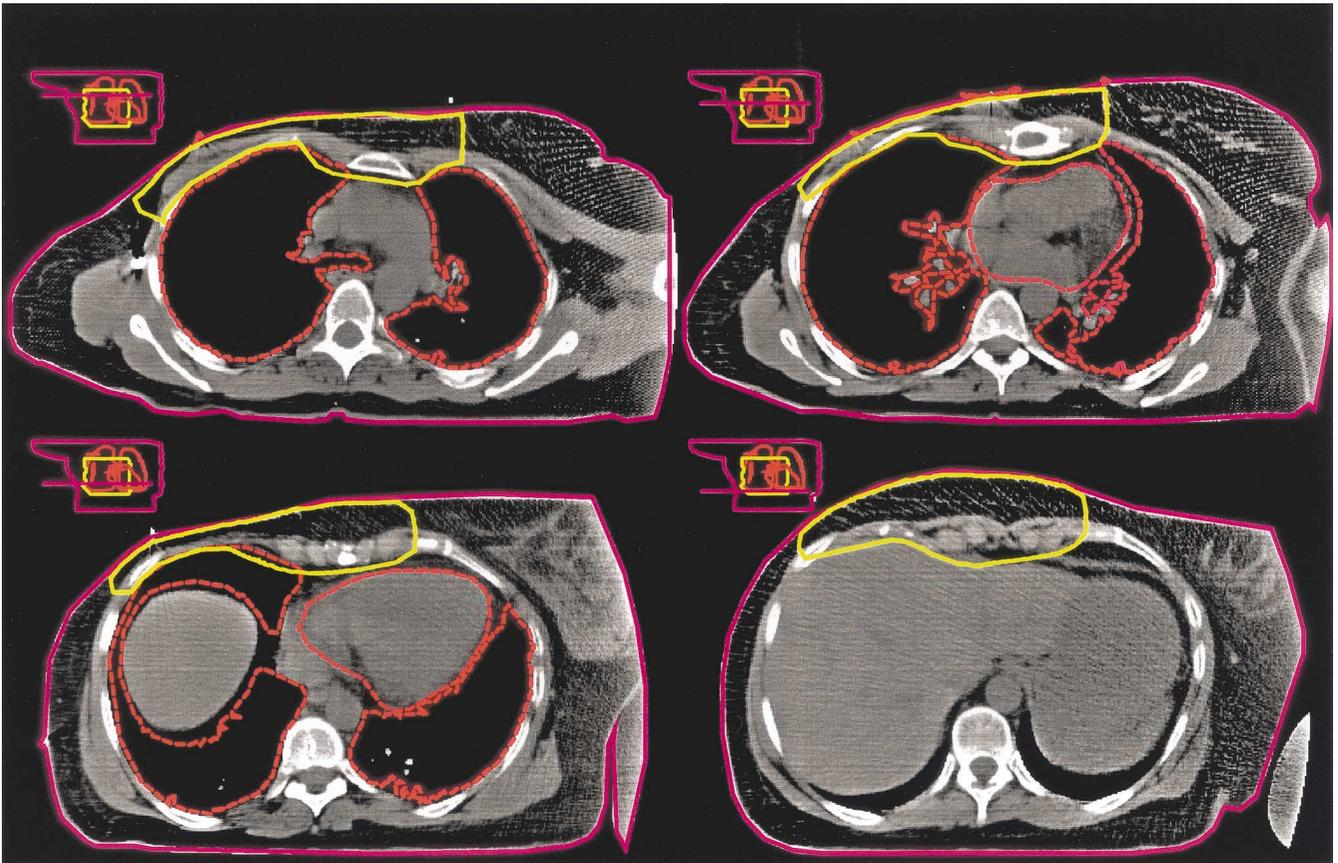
Representative CT images of a patient with a lesion in the right IMC area, with extension into the chest wall soft tissues. This lesion is in an area where IMC and tangent field junctions are normally placed.
